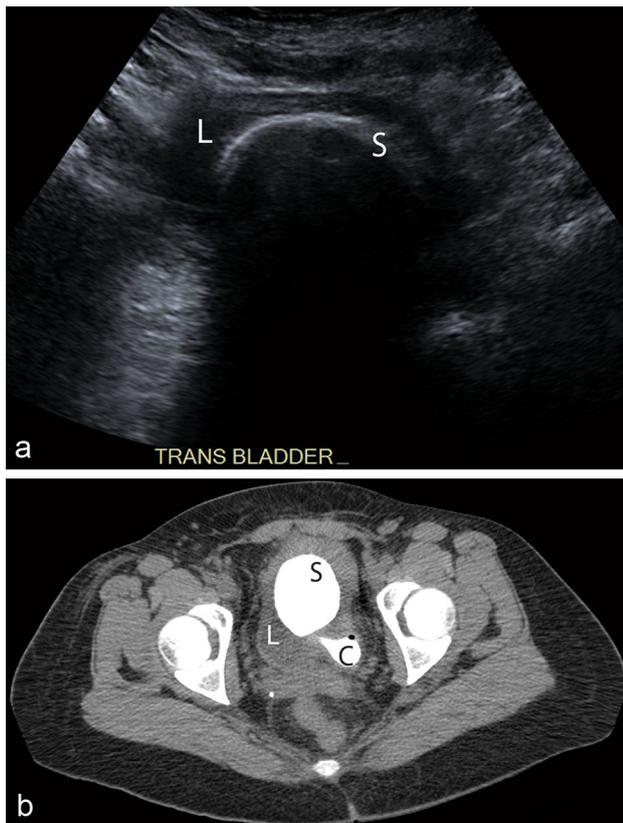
44-year-old female with a large bladder calculus. a Transverse grayscale ultrasound view of the bladder shows the anterior bladder wall and a large round calcified intraluminal mass with marked posterior acoustic shadowing. b Axial non-contrast CT shows a large calcified bladder mass, confirmed to represent a large bladder calculus. Note the presence of a left ureteral stent fragment (C) surrounded by calcification. The bladder calculus may have formed secondarily to the presence of this retained distal ureteral stent fragment. *L* bladder lumen, *S* stone, *C* calcified ureteral stent
